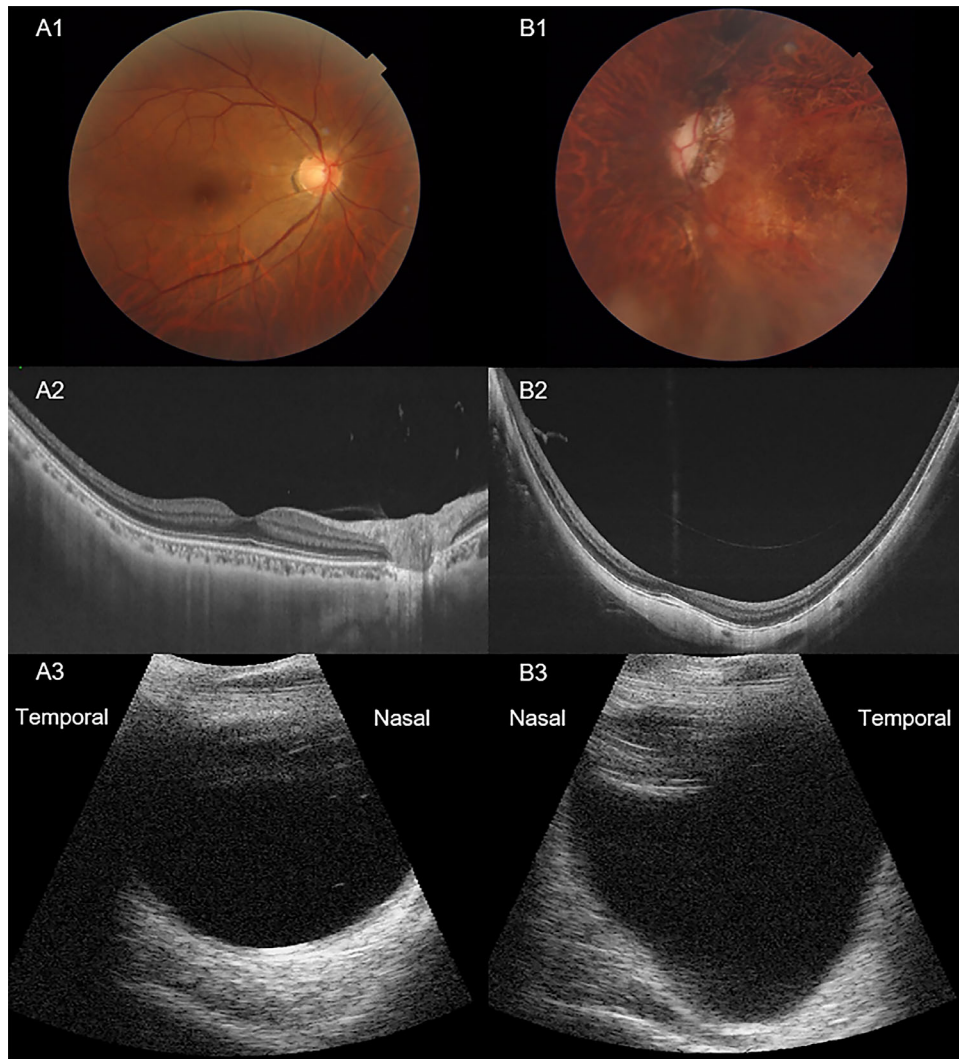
Multimodal imaging of highly myopic eyes without (A) and with (B) myopic macular degeneration (MMD) as based on fundus images (Row 1), swept source optical coherence tomography (Row 2) and B-scan ultrasonography (Row 3). The eye in column A shows absence of MMD (META-PM grade 1 – tessellated fundus, A1), early posterior vitreous detachment (paramacular PVD) with no myopic traction maculopathy (MTM, A2) and no posterior staphyloma (PS, A3). In contrast, the eye in column B shows the presence of MMD (META-PM grade 2 – diffuse chorioretinal atrophy, B1), incomplete PVD with vitreofoveal separation but persistent attachment at optic nerve) and MTM (extrafoveal schisis, B2) and PS (B3). META-PM, meta-analysis for pathologic myopia study group.⁹
